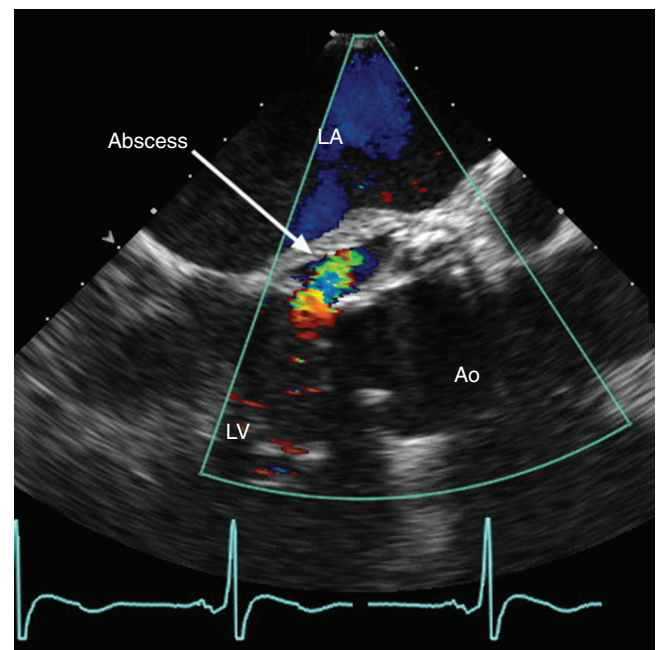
■ Pseudoaneurysm of the mitral-aortic intervalvular fibrosa (arrow) in a patient with a mechanical aortic valve, imaged by transesophageal echocardiography. Systolic flow is seen by color Doppler into the left ventricle (LV) outflow tract. Ao, Aorta; LA, left atrium.
